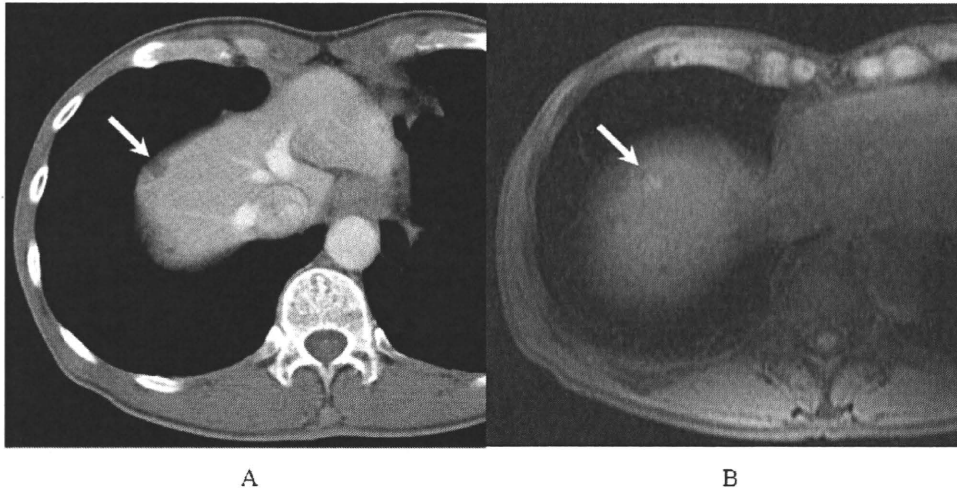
A 66-year-old woman with malignant melanoma of the left leg. The patient received surgical resection and sentinel lymph node sampling. (A) Follow-up contrast-enhanced spiral CT is detected a low attenuation nodule of the liver in segment 8 (arrow), and the enhancement of the lesion is obscure. (B) Fat suppressed transverse T1-weighted gradient-echo image shows high signal intensity nodule in segment 8 (arrow). The lesion showed obviously growth after 6 months watchful waiting. Hence, the lesion was considered to be a true hepatic metastasis.
